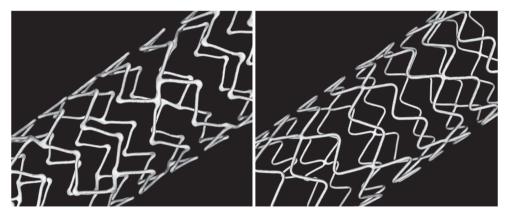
Micro computed tomography images of DES compared in DUTCH PEERS. Promus Element (left panel) and Resolute Integrity (right panel); images from ongoing bench side studies performed by C. von Birgelen and coworkers, University of Twente, Enschede, The Netherlands.
